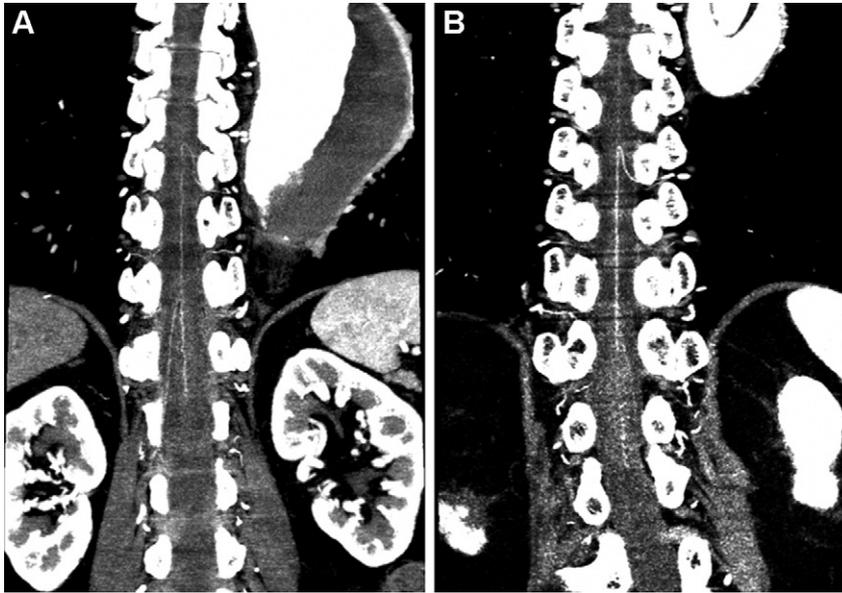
Anatomical patterns of the spinal cord feeding artery detected by multidetector row computed tomography (MD-CT) scan: (A) confluence-shaped, (B) hairpin-shaped. The confluence-shaped arteries were frequently accompanied by a more proximally located hairpin-shaped artery, as in this Figure.
